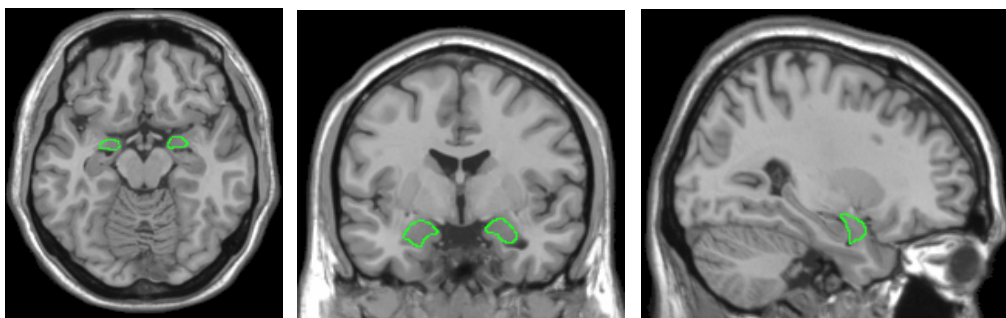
T1-weighted MRI showing boundaries for volumetric measures of amygdala (in order, axial view $z = -15$, coronal view $y = -2$, and sagittal view $x = 29$).
